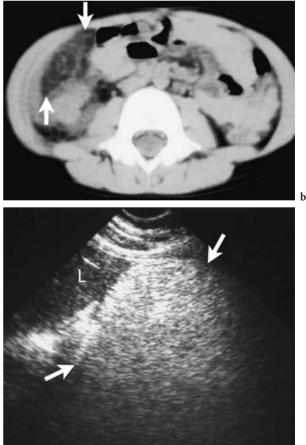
Omental infarction. a Hyperechoic mass just behind the abdominal wall (*arrows*). b Axial CT image shows an area of fat stranding indicating inflamed mesenteric fat (*arrows*). c Another patient. Longitudinal US at the subhepatic region shows a hyperechoic mass just underneath the anterior abdominal wall that progressively attenuates the sound suggesting a fat origin (*arrows*). *B*,dilated bowel loops; *L*, liver
